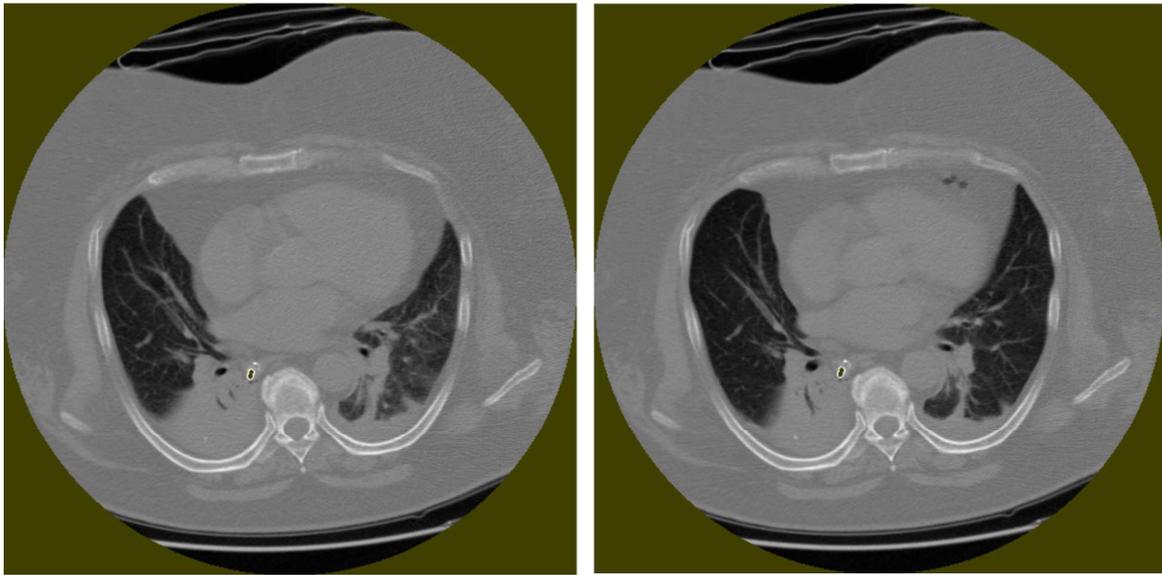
Computed tomography and CT scan in a patients with no CT scan recruitment*
